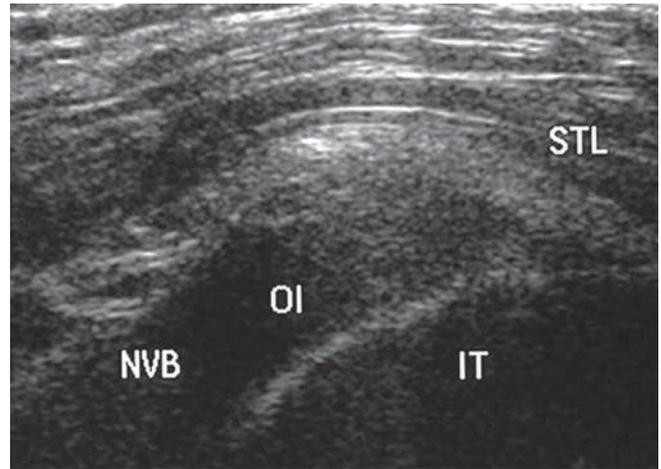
Transverse ultrasound scan of STL at same level as Fig. 6. [OI = obturator internus, NVB = pudendal neurovascular bundle, IT = ischial tuberosity].
